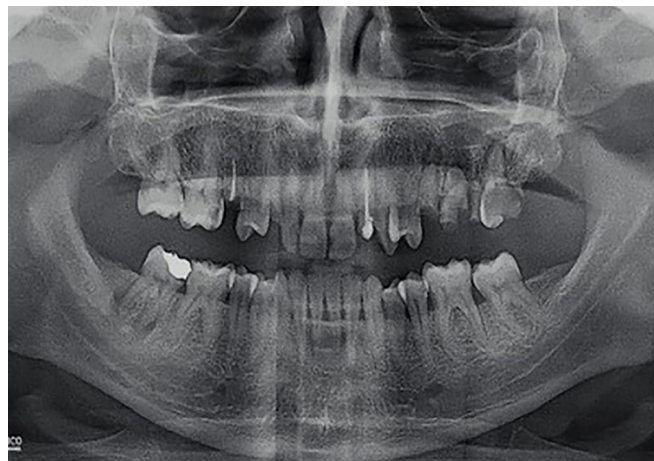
Orthopantomography.
